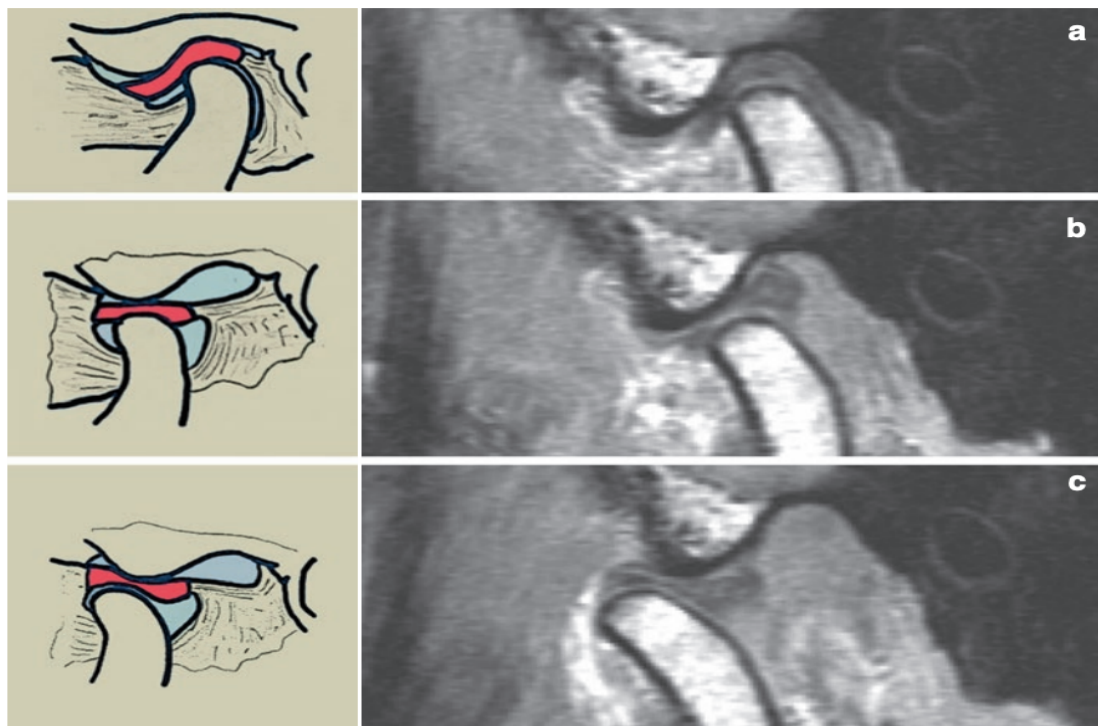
MRI of a normal joint. MRI of a normal joint: a) closed, b) partially open, and c) open mouth positions (Rozylo-Kalinowska & Orhan, 2019).
